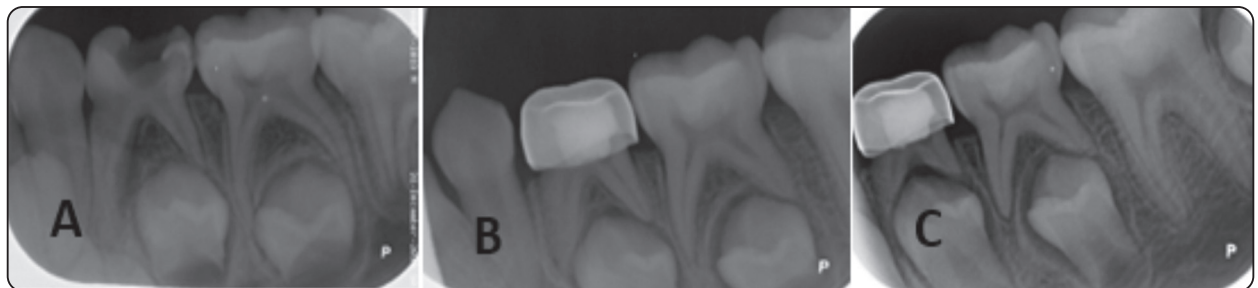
Radiographic images showing lower Left primary molar after DPC using MTA: (A)- after 3 months follow up (B)-after 9 months follow up (C)- after 12 months follow up
